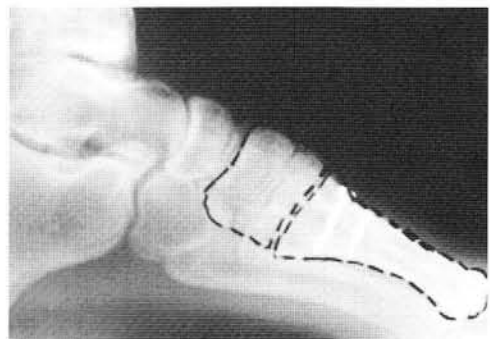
Five year postoperative lateral radiograph.
